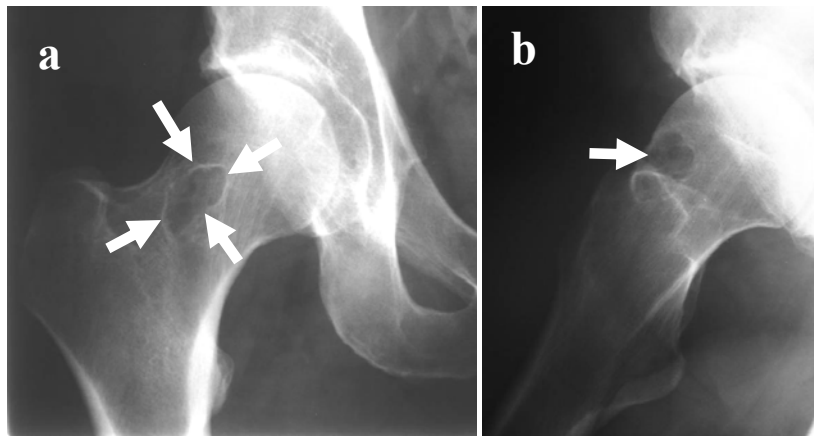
Pre-op radiographs (Case 1). Anterior – Posterior (AP) (a) and Lateral (b) radiographs of the right hip, Case 1. The lesion is seen residing in the anterior third of the femoral neck, distorting the anterior cortex.
